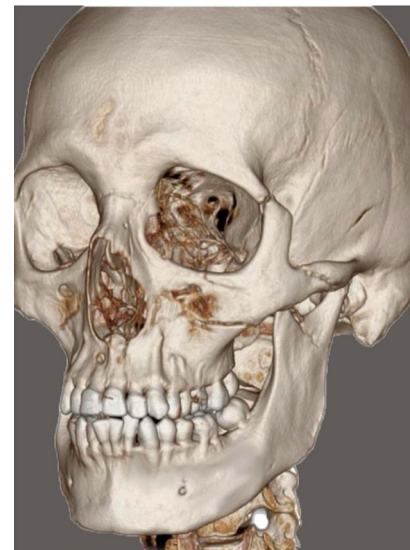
Radiographic picture of preoperative 3D Computed-Tomography Scan.
